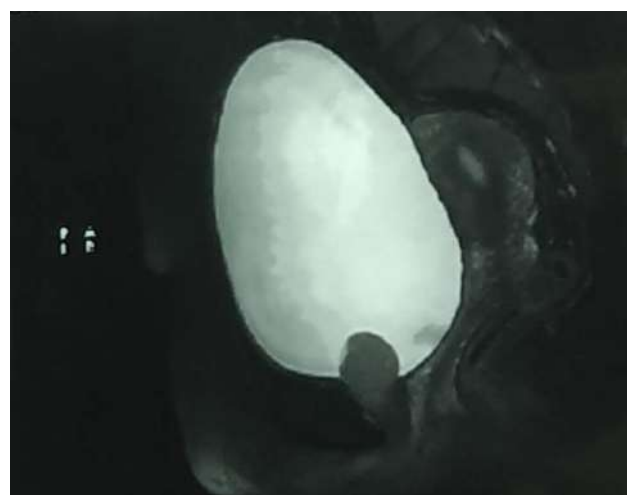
T2 images of MRI showing mass near the bladder neck
